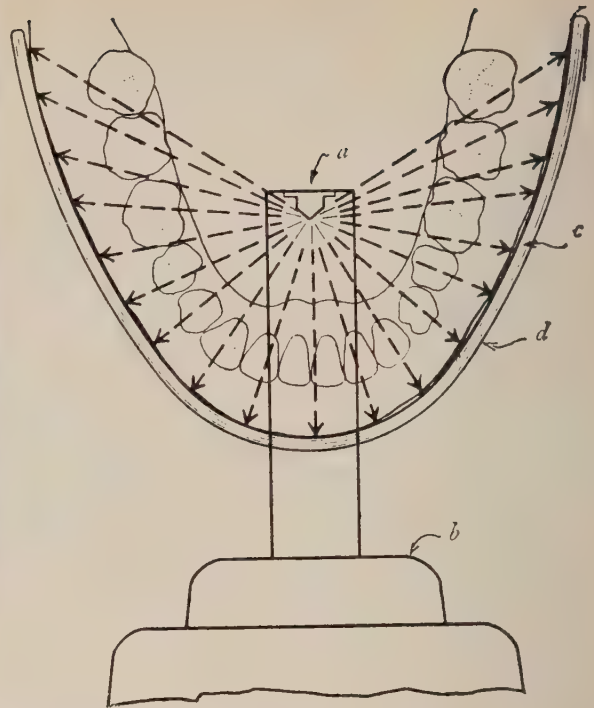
Panoramix principle. X - ray source and patient are stationary. Anode source of x-ray at (a); film at (c). (Blackman, Sydney and Poyton, H.G. A manual of dental and oral radiography. Bristol, Wright, 1963.)
